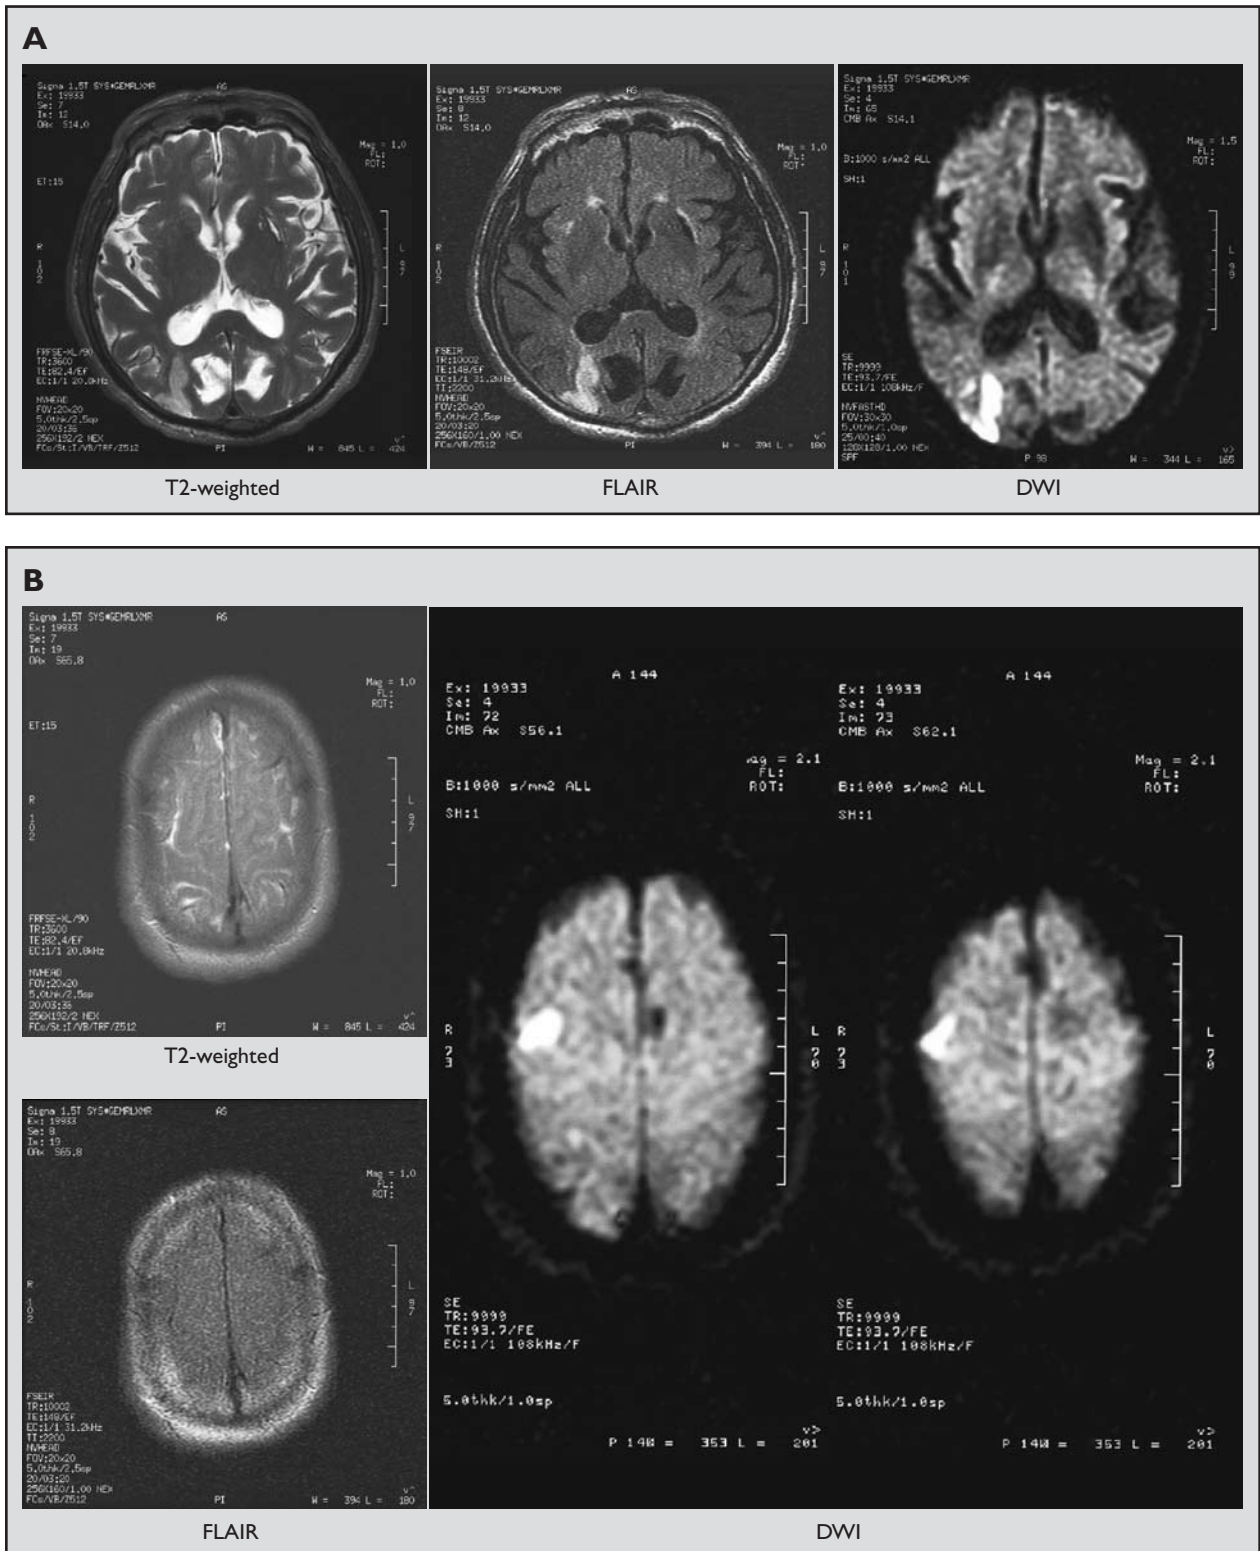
Acute ischemic stroke demonstrated on magnetic resonance imaging sequences with T2-weighted, fluid attenuation inversion recovery (FLAIR), and diffusion-weighted imaging (DWI). (A) Matching areas of stroke seen on T2-weighted, FLAIR, and DWI. (B) Increased sensitivity in detecting stroke on DWI not seen with T2-weighted or FLAIR imaging sequences.
